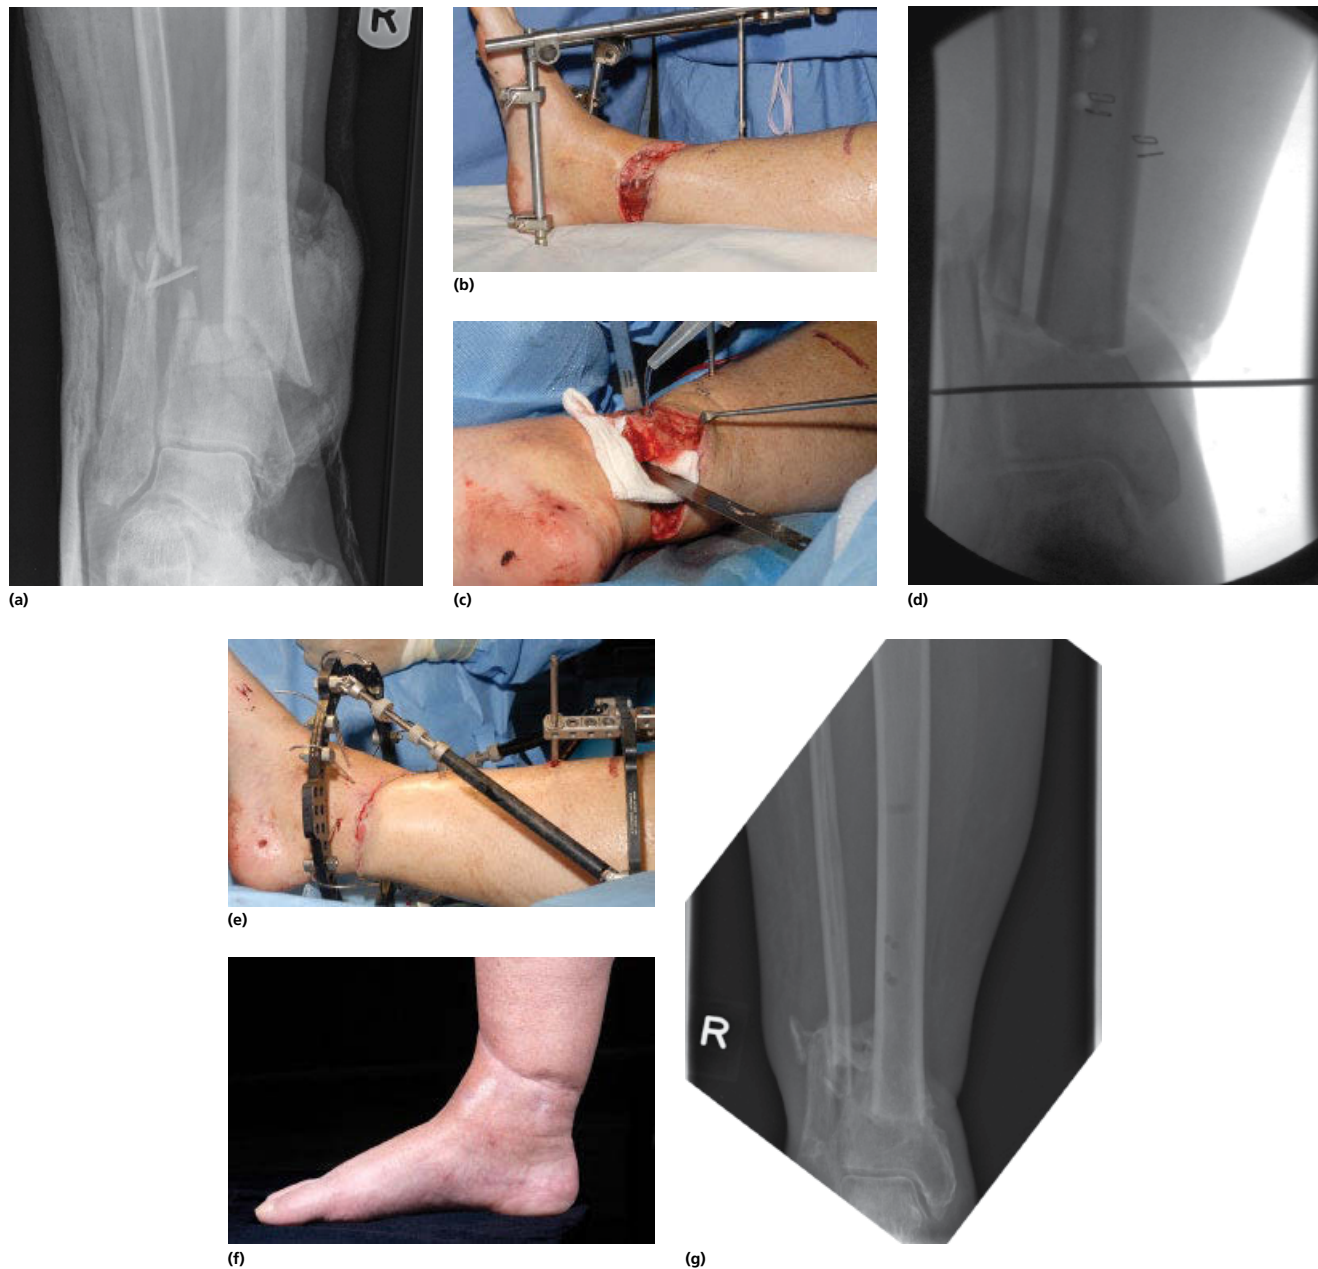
Acute shortening of distal tibial fracture in an 84-year-old female. (a) The initial radiograph showing a displaced comminuted fracture of the distal tibia and (b) the transverse wound extending posteriorly to the medial fascial perforating vessels, precluding the use of local fasciocutaneous flaps. (c) Bone resection using a water-cooled oscillating saw. (d) Intraoperative radiographs showing acute reduction with 'male-female' fashioning of fracture ends. (e) Acute tension-free wound closure after shortening. (f) The final clinical appearance and (g) final radiograph showing fracture union.
